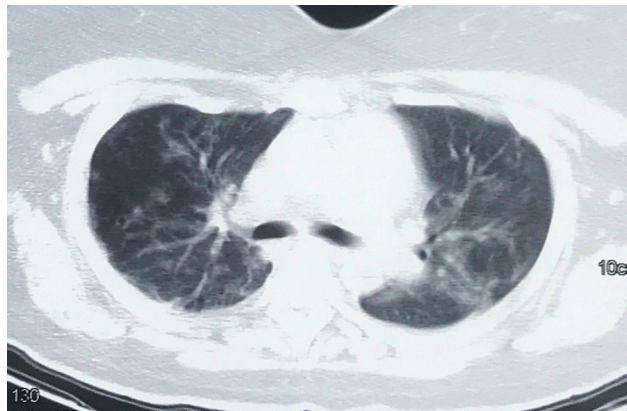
Contrast computed tomography thorax showing bilateral ground glass opacities and consolidative changes.
